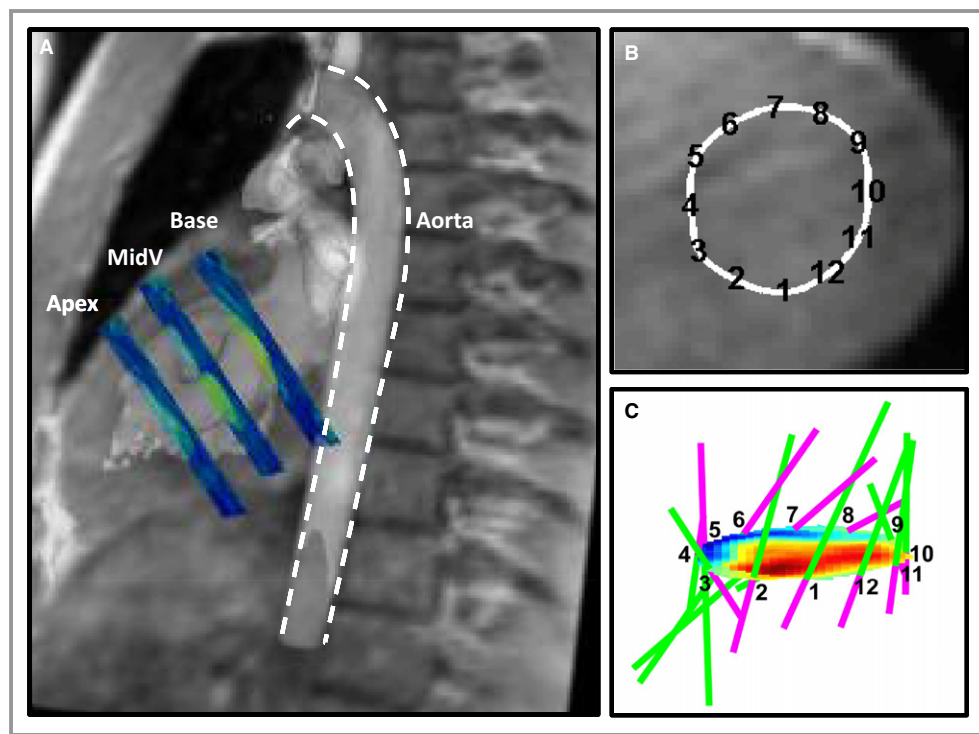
Methodology for magnetic resonance imaging analysis. A, Example of 2D plane selection from the 3 regions (base, midV, and apex) through the human LV. Planes are color-coded for velocity. The aorta is outlined and labeled for reference. B, Example of manual segmentation of the LV lumen from a 2D plane. C, Intraventricular blood flow velocities (color scale red to blue); lines show wall shear stress magnitude and direction (green) and oscillatory shear index (purple) magnitude. 2D indicates 2-dimensional; LV, left ventricle; midV, midventricle.
